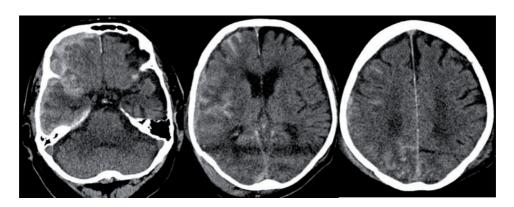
First CT-scan of presented case.
